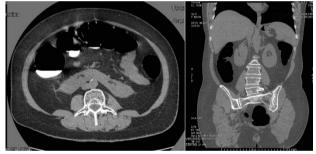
CT axial and sagittal images showing the fused kidney.
